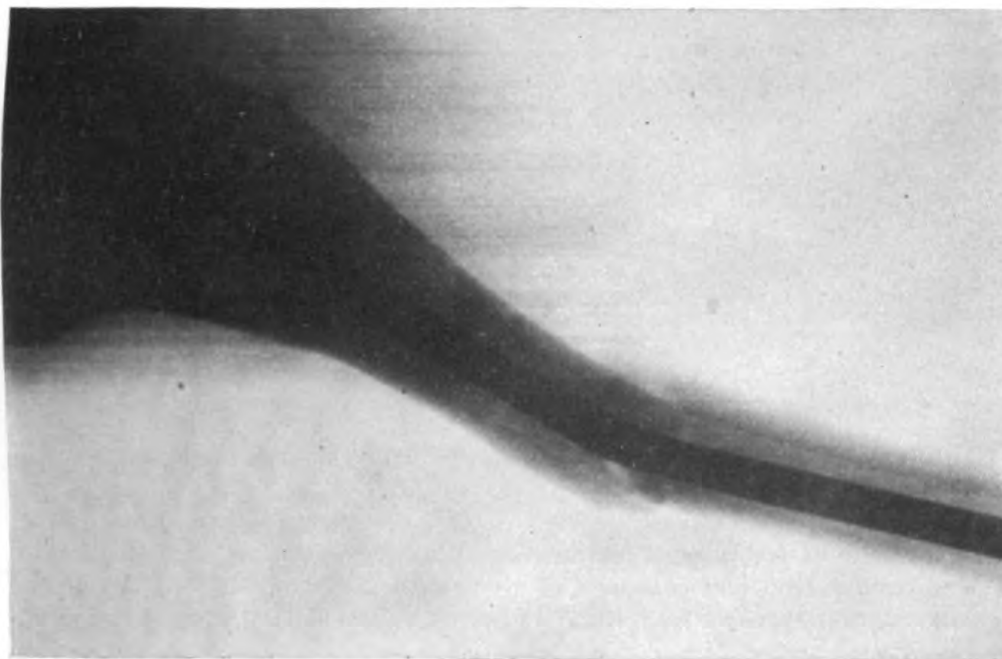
Case 3. Postoperative lateral x-ray at 5 months.
